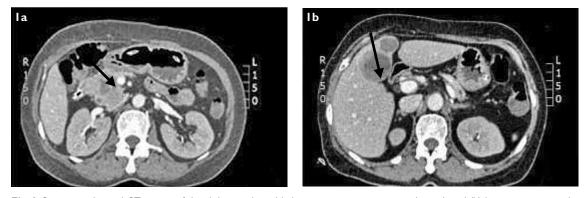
I Contrast-enhanced CT images of the abdomen show (a) the primary pancreatic mass (arrow); and (b) liver metastasis in the segment (arrow).
